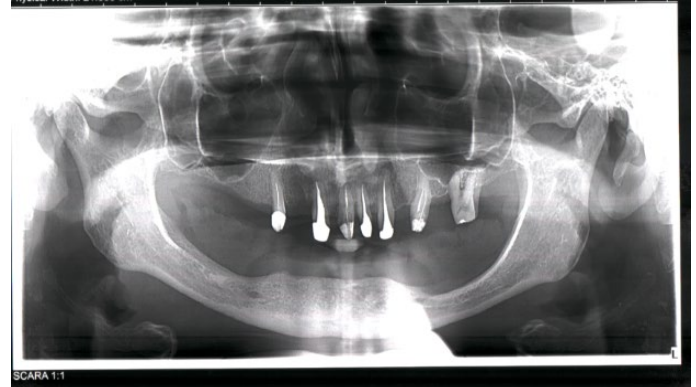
OPT X-ray performed three weeks after initiation of pulsed short wave therapy. Remineralization of the maxillary alveolar bone structure three weeks after onset of pulsed short wave therapy and apical resection, and four weeks after completion of closed periodontal curettage is seen.
